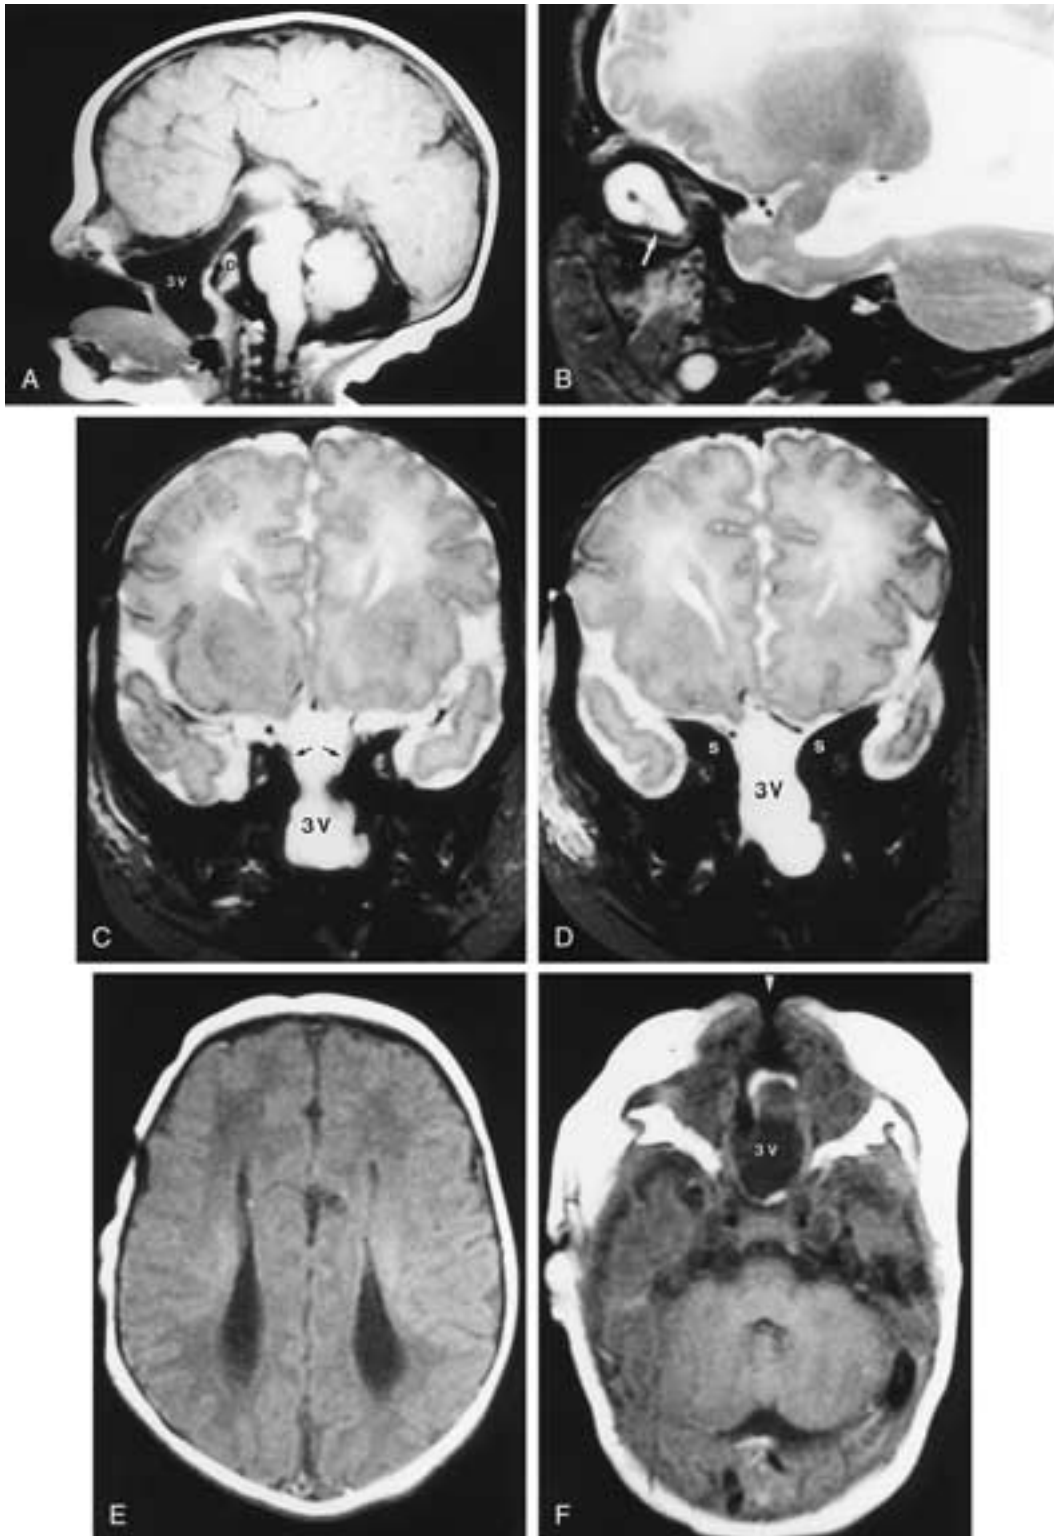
Craniofacial-cerebral dysraphism. True midline cleft upper lip. A, Midsagittal T1-weighted MR image shows a transsphenoidal-ethmoidal cephalocele, with the third ventricle (3V) and optic apparatus protruding downward through the defect in the sphenoid bone immediately anterior to the dorsum sellae (D) to rest on the tongue. The corpus callosum is absent. B, Sagittal T2-weighted MR image through the ocular globe demonstrates microphthalmia with coloboma (arrow). C and D, Coronal T2-weighted images through the cleft in the sphenoid (S). The cavernous sinuses (arrows) form the lateral walls of the hernia ostium. E and F, Axial T1-weighted images display the callosal agenesis (E), the ovoid contour of the third ventricle (3V) within the midline defect in the sphenoid, and the midline cleft upper lip (arrowhead) (F).
